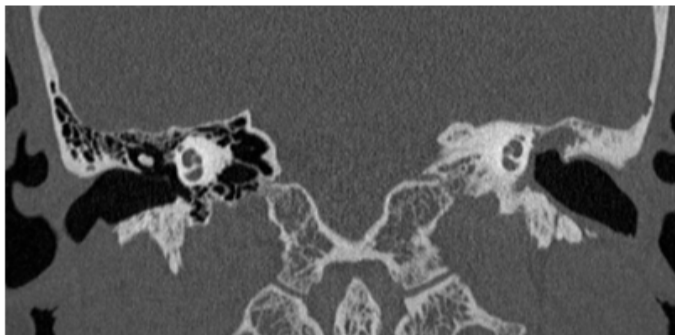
Coronal HRCT image shows non-dependent soft tissue density lesion in left Prussak's space extending into left epitympanic space with erosion of scutum s/o Left Cholesteatoma with erosion of scutum
